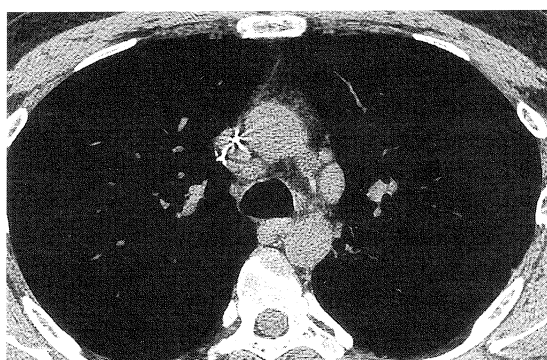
1mm HRCT scan at level of aortopulmonary window displayed at mediastinal settings.
